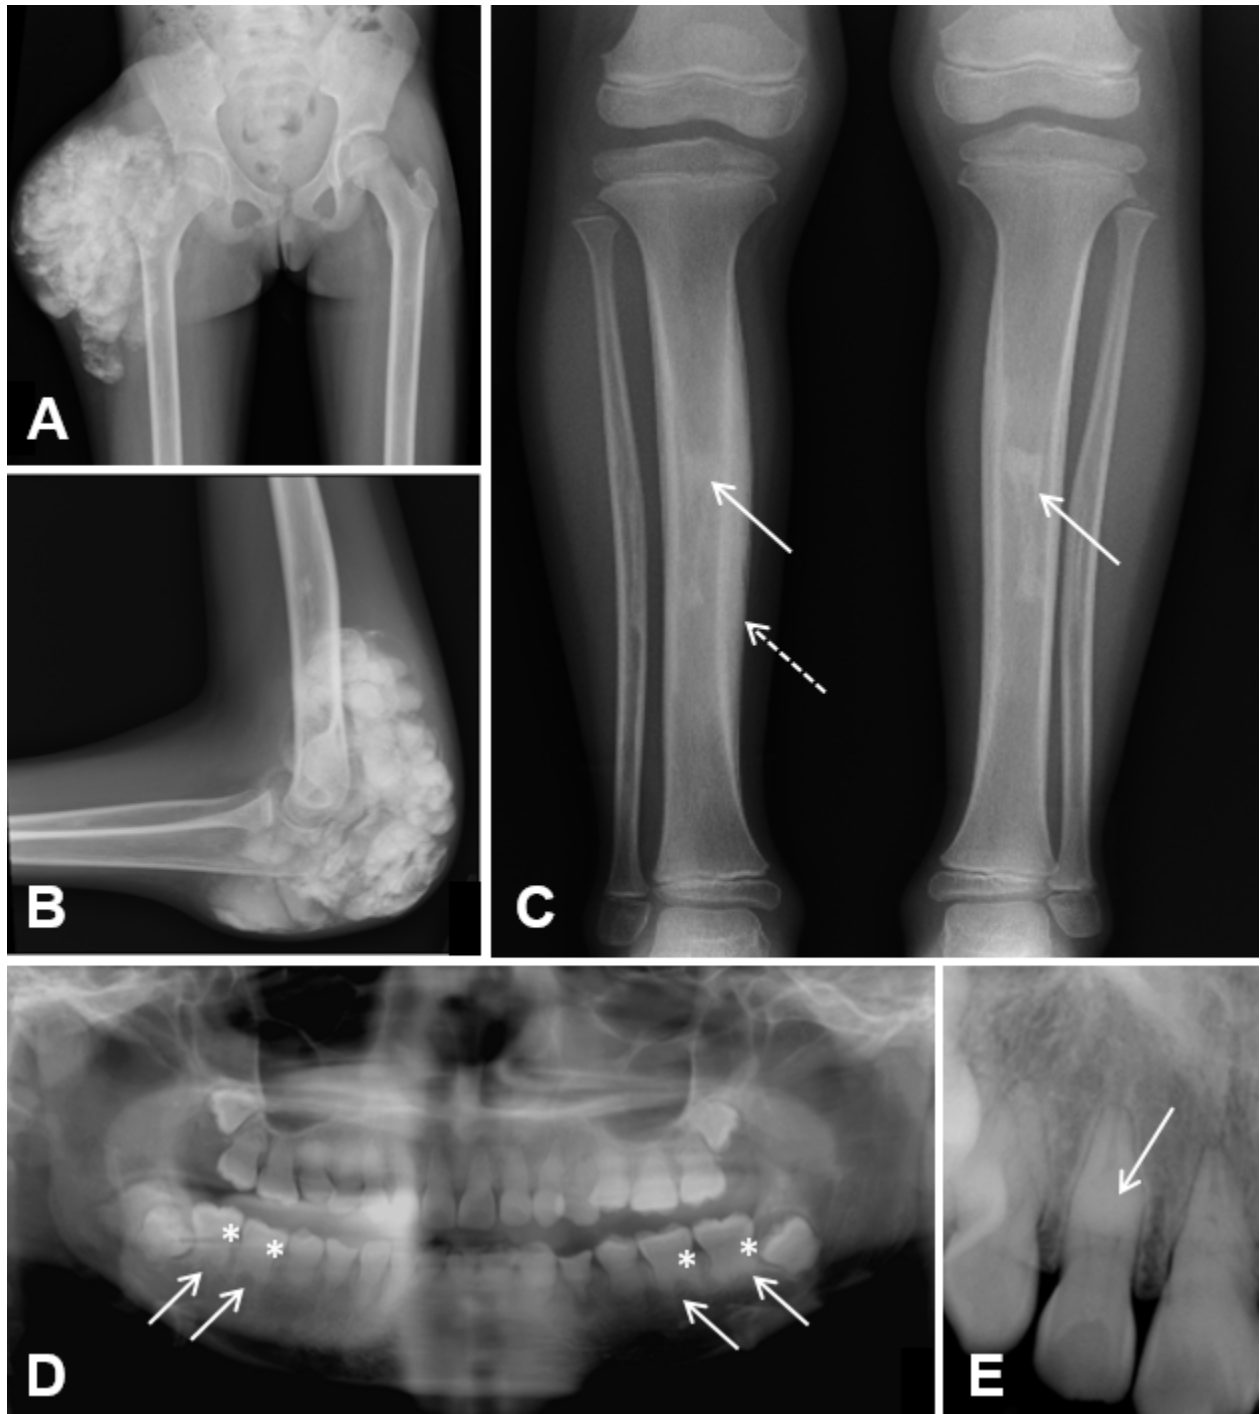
A&B. Radiographs in a child with hyperphosphatemic familial tumoral calcinosis showing tumoral calcinosis of the lateral proximal femur (A) and elbow (B)
